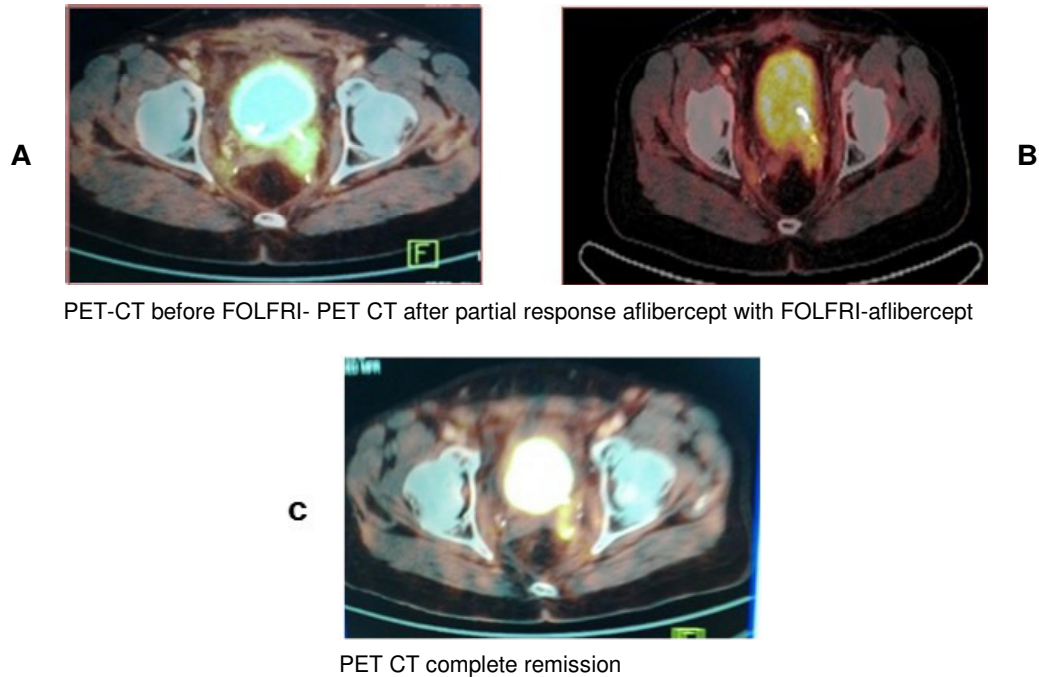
(A) base line PET- CT before aflibercept combination, (B) PET_CT first evaluation showing partial remission of left iliac lymph-node invading left ureter, (C) PET-CT showing complete disappearance of left iliac lymph-node leaving dilated left ureter
